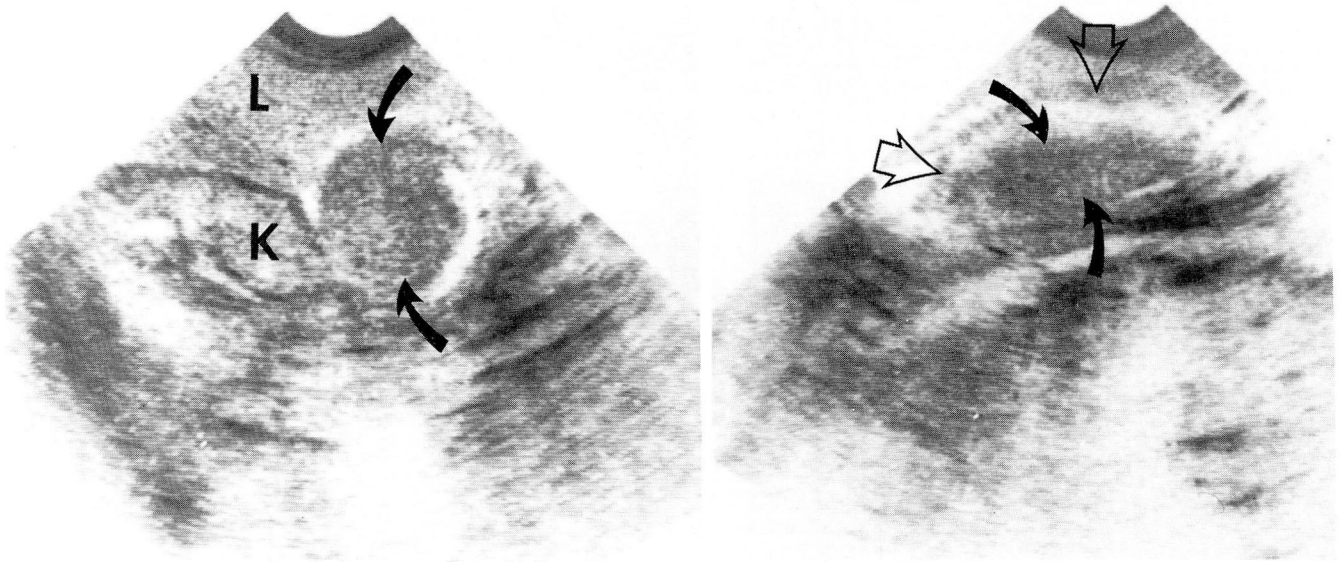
A. Transverse sector ultrasonogram, right upper quadrant of the abdomen. A large echogenic mass is seen in the center of the gallbladder (curved arrows) (*L* = left lobe of liver; *K* = kidney).
